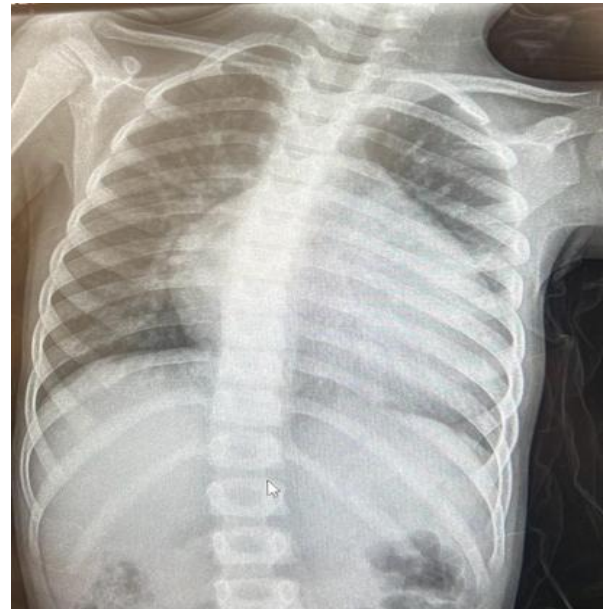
Standard chest X-ray showing cardiomegaly in one of our patients.
